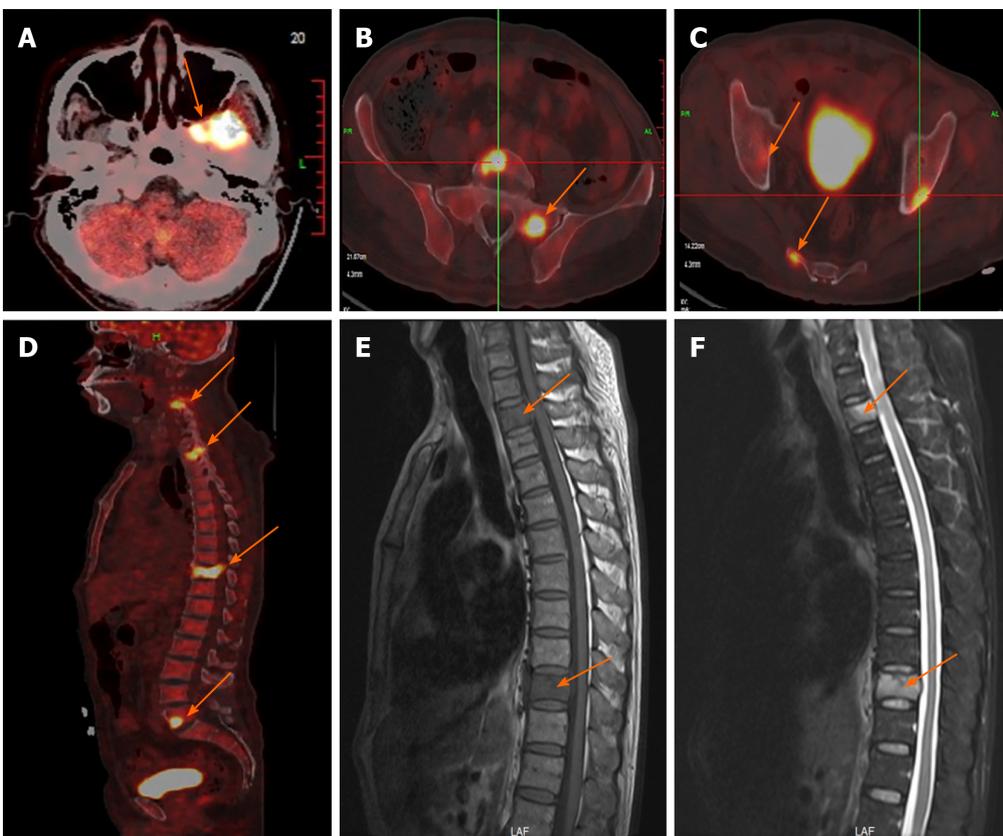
Thoracic magnetic resonance imaging. A and B: Thoracic enhanced magnetic resonance imaging showed obvious T2 and T10 vertebral bone destruction (orange arrows); C-F: Positron emission tomography-computed tomography showed increased 18F-fluorodeoxyglucose avidity involving the left sphenoid wing, the C4-5, T2, T10, L5, S1, and S5 vertebrae; the right humeral head, both sides of the humerus, and the right proximal femur. Multiple osteolytic lesions were identified as hypermetabolic lesions with a maximum standard uptake value of 18.64; different degrees of bone destruction can be observed in corresponding sites (orange arrows).
